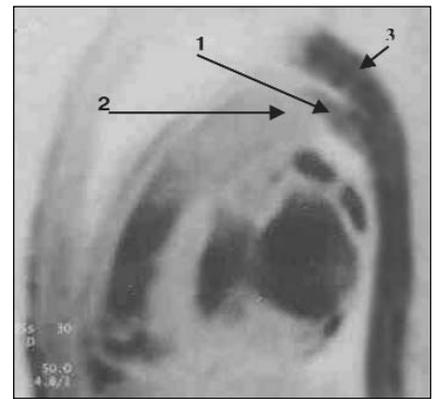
Patient K., five-years-old. MRI of the heart and great vessels before the embolization (lateral view).
